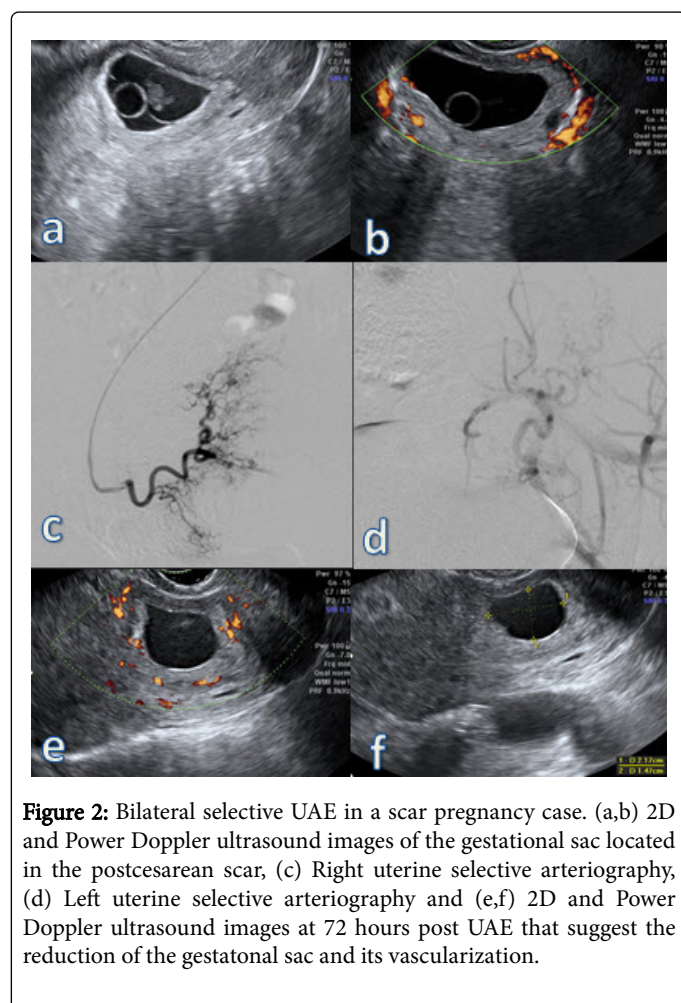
Bilateral selective UAE in a scar pregnancy case. (a,b) 2D and Power Doppler ultrasound images of the gestational sac located in the postcaesarean scar, (c) Right uterine selective arteriography, (d) Left uterine selective arteriography and (e,f) 2D and Power Doppler ultrasound images at 72 hours post UAE that suggest the reduction of the gestational sac and its vascularization.
